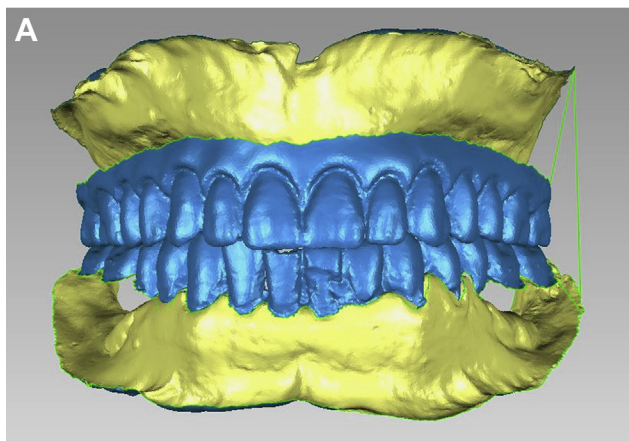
(A) CAD/CAM design of dentures in software based on information acquired with cone beam computed tomography, intraoral scans, and facial surface scan. (B) Milled monolithic dentures based off of software generated design.
